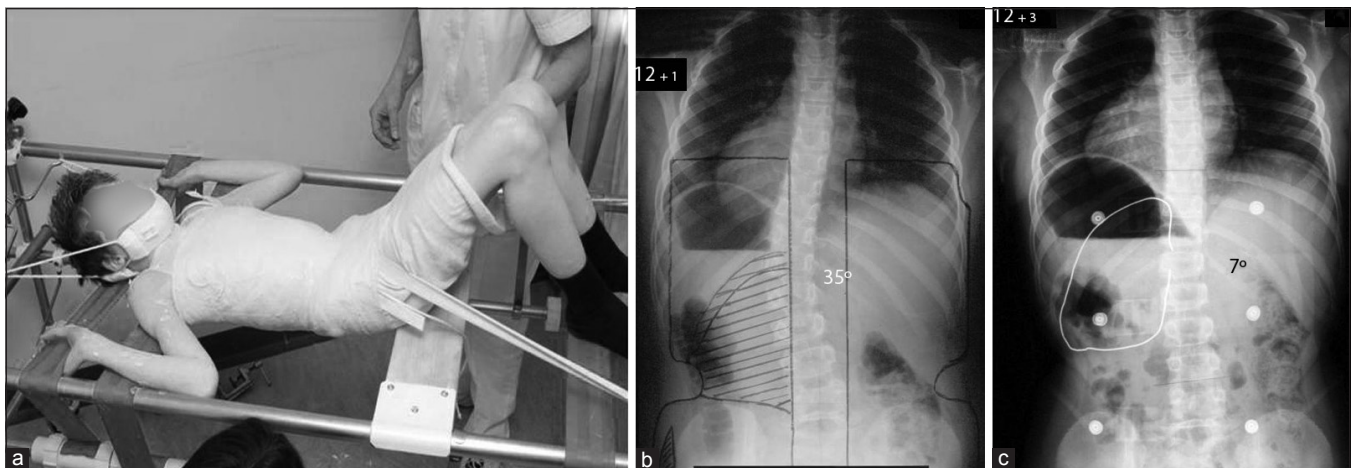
(a) Clinical photograph of a male patient showing a thoracolumbar scoliosis undergoing plaster molding for a Boston brace using the Risser frame and longitudinal traction (b) initial posteroanterior radiograph of the spine showing the template for positioning of the corrective pad. (c) repeat radiograph of the spine (at 6 weeks) which shows adequate location of the apical pad (wire marker) and good support of the spine with the scoliosis corrected from 35 to 7°
